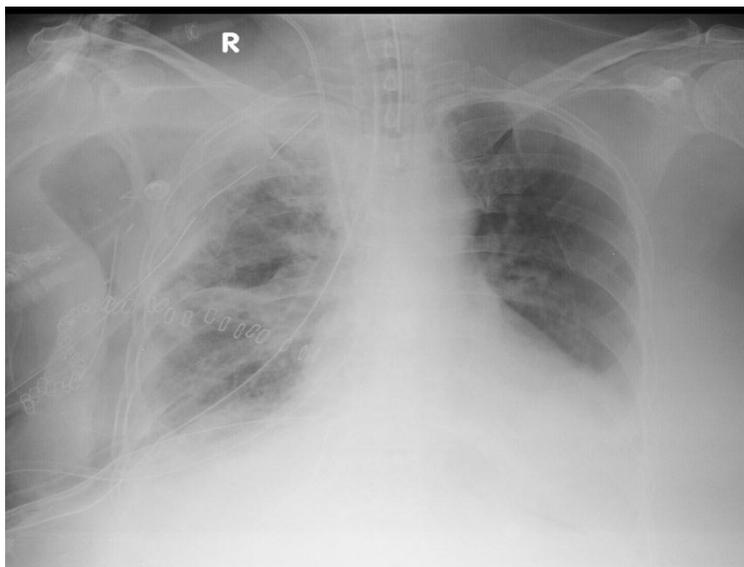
Chest radiograph taken after surgical intervention showing decreased right pleural effusion with no obvious evidence of pneumothorax. Inter-costal drains are seen in situ.
